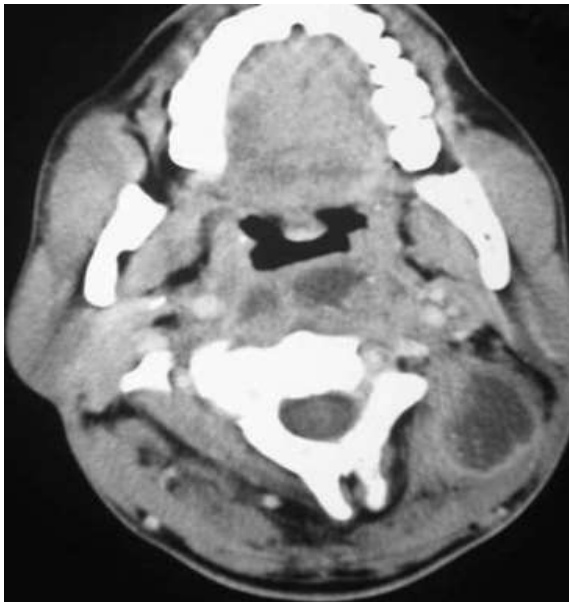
Abscesses in the retropharyngeal and parotid space on CT
